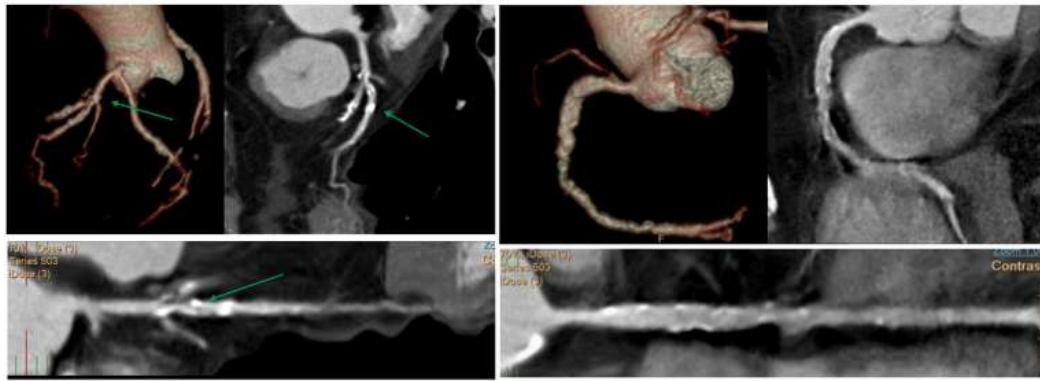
CT Coronary Angiography (CCTA) revealed a calcified plaque with luminal stenosis (60–70%) in the proximal left anterior descending (LAD) artery and a mixed plaque with severe stenosis (90%) at the ostium of the first diagonal (D1) branch.
